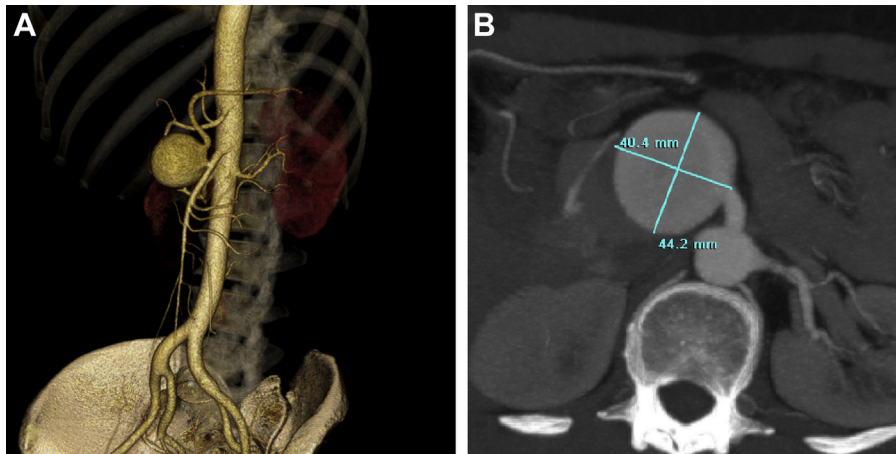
A, A three-dimensional reconstruction shows the giant anomalous splenic artery (SA) aneurysm (SAA) arising from the superior mesenteric artery (SMA). B, A transverse computed tomography angiogram (CTA) image manifests the size of the anomalous SAA.
